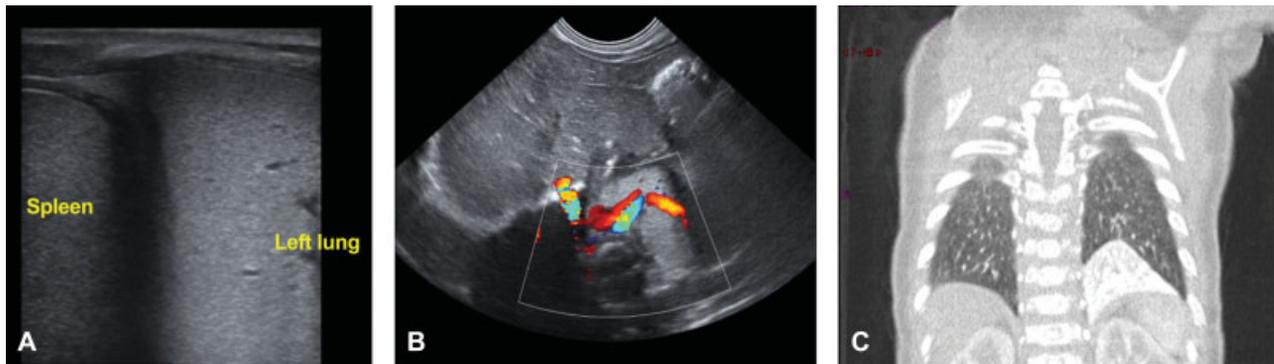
(A) LUS on DOL 1: complete atelectasis of the left lower lobe with echogenicity similar to the spleen. (B) Color Doppler examination: abnormal feeding vessel branching from the thoracic aorta. (C) CT scan at 6 months of life; PS appearing as consolidation of the left lower lobe. CT, computed tomography; DOL, day of life; LUS, lung ultrasound; PS, pulmonary sequestration.
